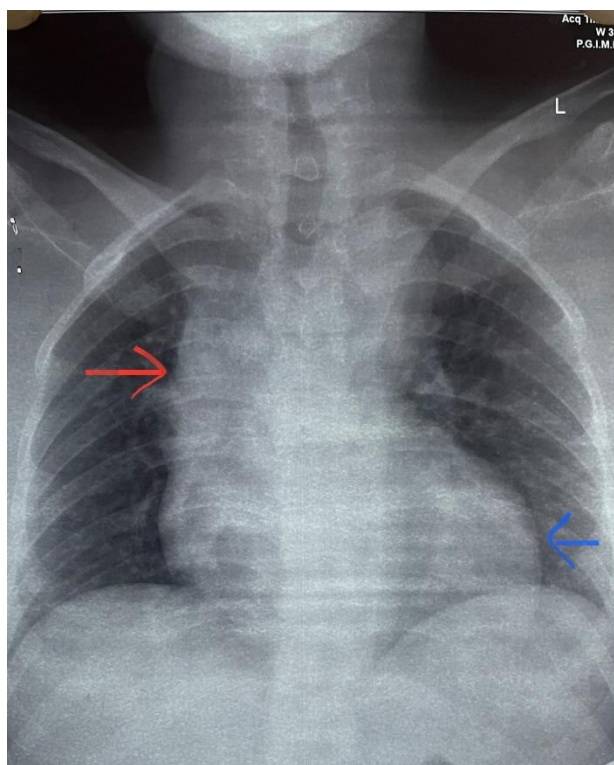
Chest X-ray of the patient showing a dilated ascending aorta (as indicated by red arrow) and enlarged left ventricle (as indicated by blue arrow) which are suggestive of aortic stenosis.
